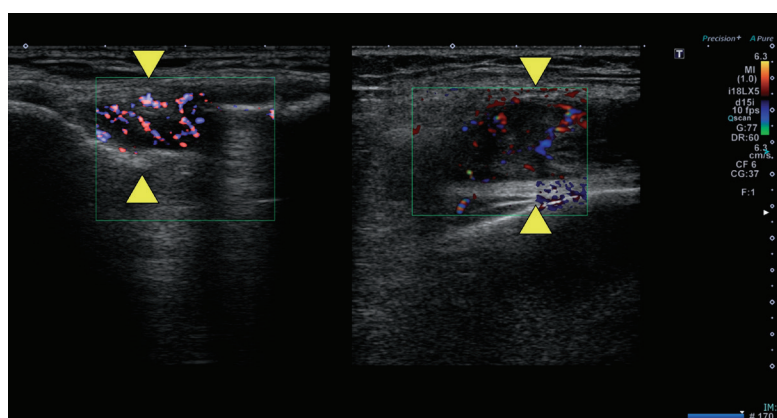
Ultrasonography showing a clot, thickened synovial membranes (both ends of the thickened synovium are indicated by  $\triangle$ ), and increased blood flow within the right knee bursa. However, no extravasation was observed.
